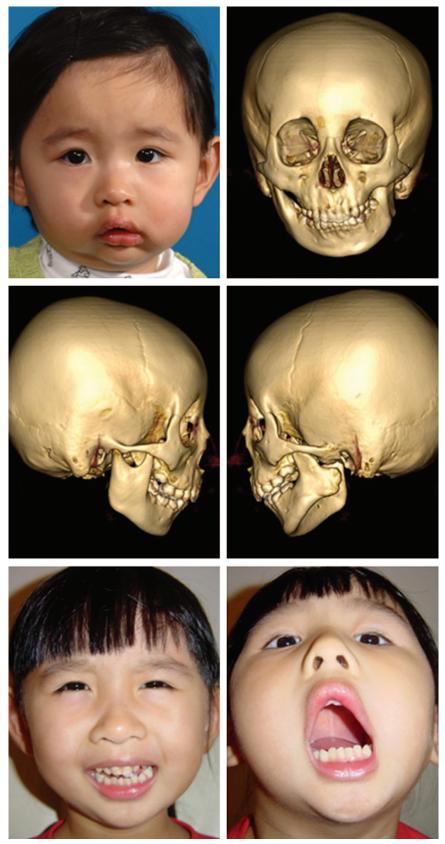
Case 2. Preoperative images (*above* and *center*) of a 22-month-old girl (patient 18) who acquired an infection resulting in intracapsular ankylosis. Computed tomography
